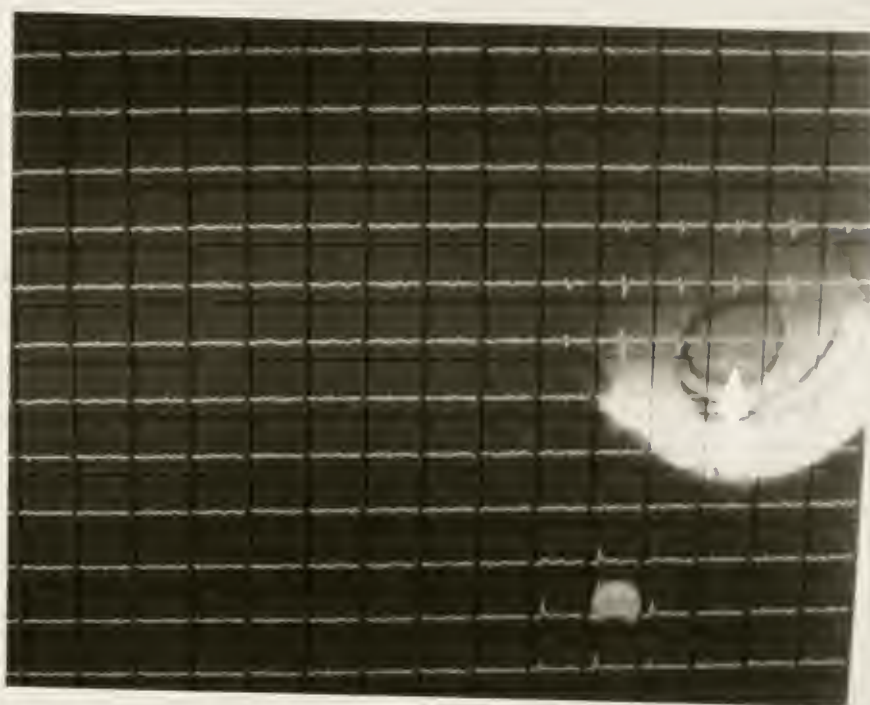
Photograph of CSI data superimposed on an axial MR image of tumor. The arrow points to the femur. Surrounding the black cortex of the femur on the left, right and top, is the malignant tumor appearing grey. The white areas below the femur are mostly fat. The small light grey object at the bottom of the photograph is the external standard.
